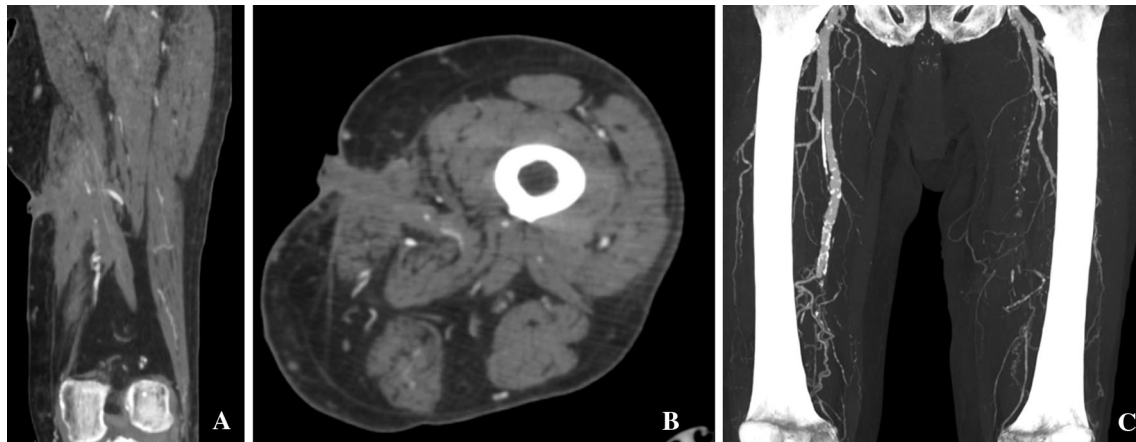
CT angiography. Coronal (A) and sagittal (B) multiplanar reconstruction showing fistula. C Maximum intense projection showing superficial femoral artery occlusion with no hemorrhage
